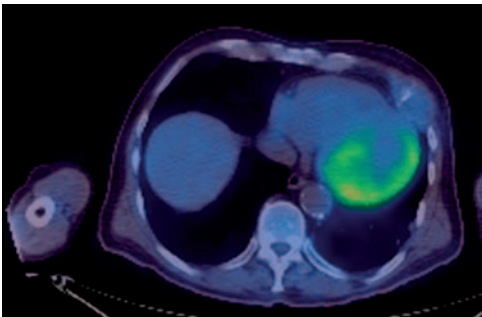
This montage demonstrates an expansible lytic lesion in one of the left-sided ribs from metastatic renal cell cancer, clearly seen on thoracic CT. However a FDG-PET shows negative uptake.
